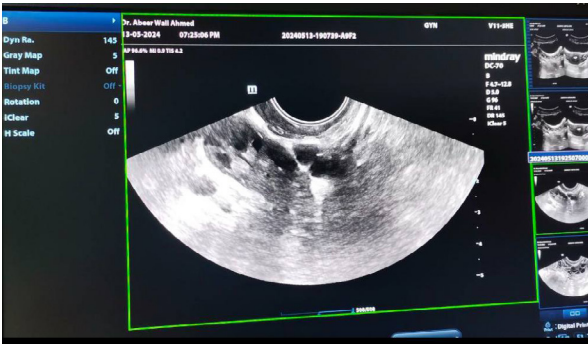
Transvaginal ultrasound reveals a significantly enlarged right ovary, characterized by peripherally distributed follicles and a centrally located echogenic stroma
